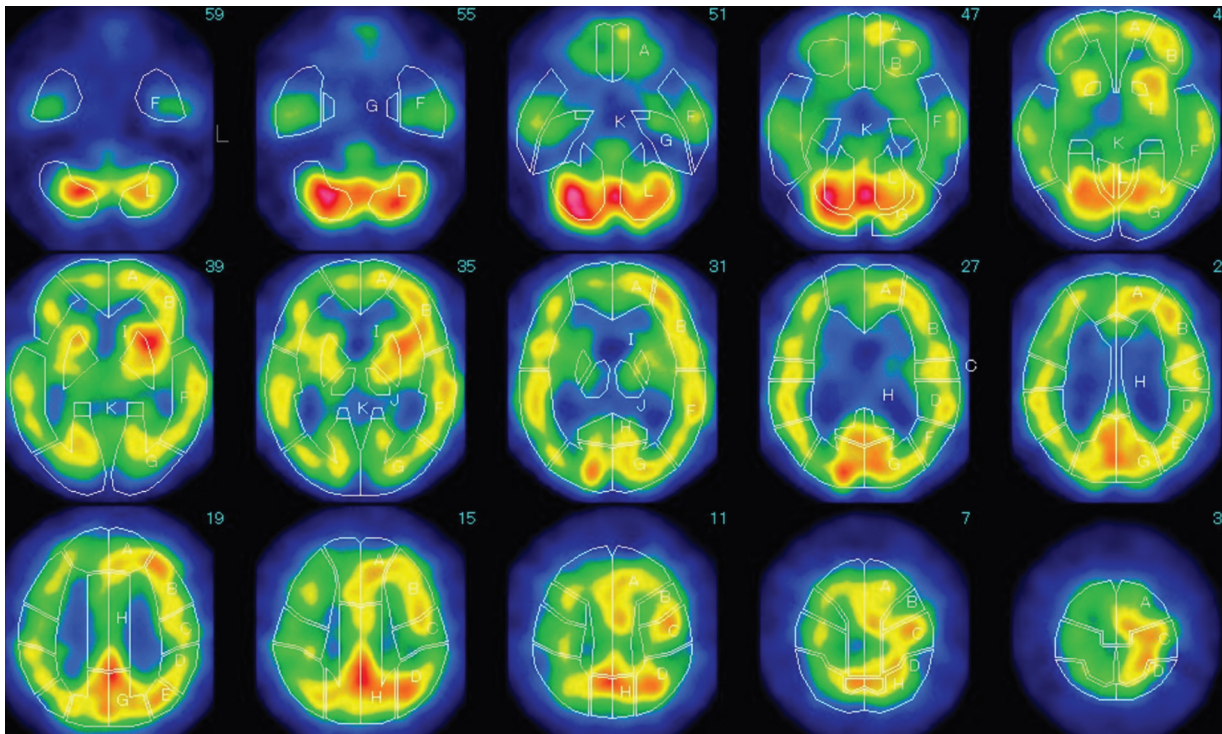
Single-photon emission computed tomography showing that cerebral blood flow in the right cerebrum has slightly decreased.
